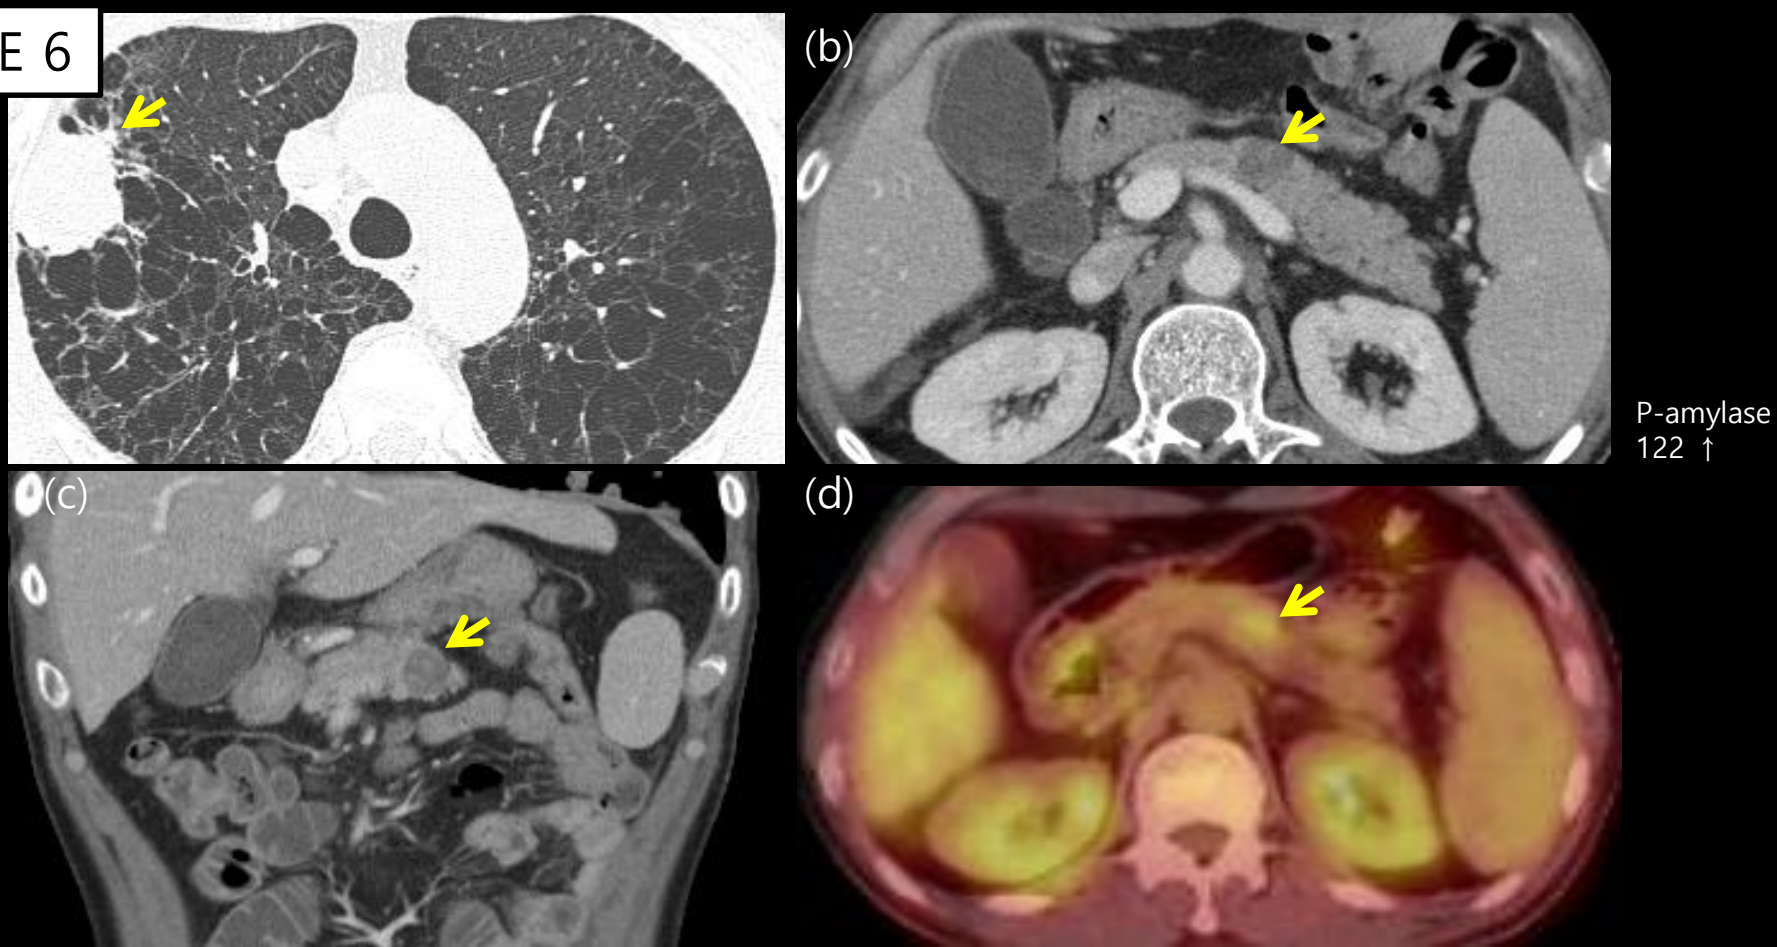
57 years old man presented with acute pancreatitis by metastatic pancreatic cancer. (a) Known primary lung cancer lesion (yellow arrow) in axial contrast-enhanced CT image obtained with lung window setting previously confirmed by pathology. (b), (c) Axial contrast material-enhanced abdomen CT images & coronal oblique reconstructed image show diffuse pancreatic swelling without peripancreatic infiltration, fluid collection and poorly enhancing nodular lesion (yellow arrow) in junction of pancreatic body & tail. Pancreatic duct are not remarkably dilated. (d) Focal high FDG uptake (yellow arrow) in PET CT indicated metastatic mass lesion of pancreas.
